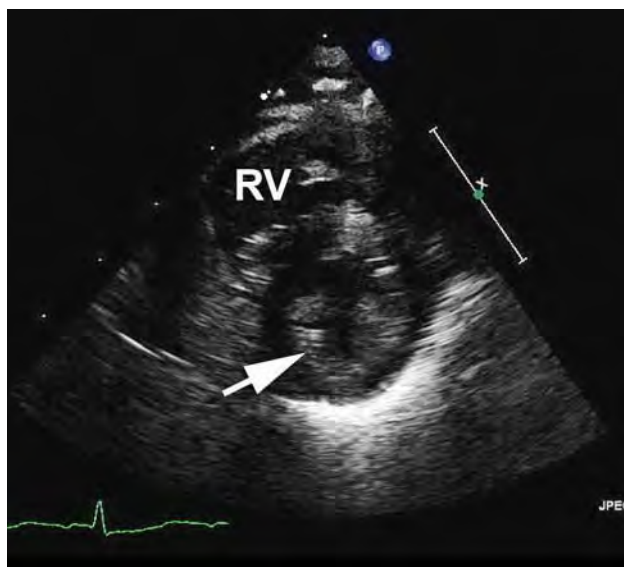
Parasternal short-axis view showing the right and left ventricles in short axis. The left ventricle (arrow) is significantly hypertrophied. RV, right ventricle.
